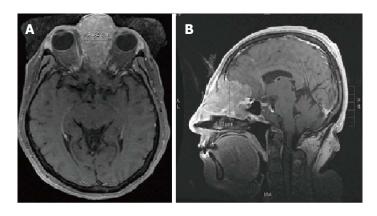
T1 magnetic resonance imaging of sinonasal undifferentiated carcinoma neoplasm prior to treatment. A: Axial T1 magnetic resonance imaging (MRI) and B: Sagittal T1 MRI show an avidly enhancing mass centered in the left ethmoid air cells with extension into the left frontal sinus with adjacent retained fluid and maxillary sinus with erosion of the medial orbital walls bilaterally, left greater than right. The majority of the ethmoid air cells are replaced by the neoplasm. Extension through the cribriform plate is noted with involvement of the left olfactory lobe, predominantly along the gyrus rectus. There is extensive surrounding edema in the left frontal lobe, extending back to the frontal hom of the left lateral ventricle.
